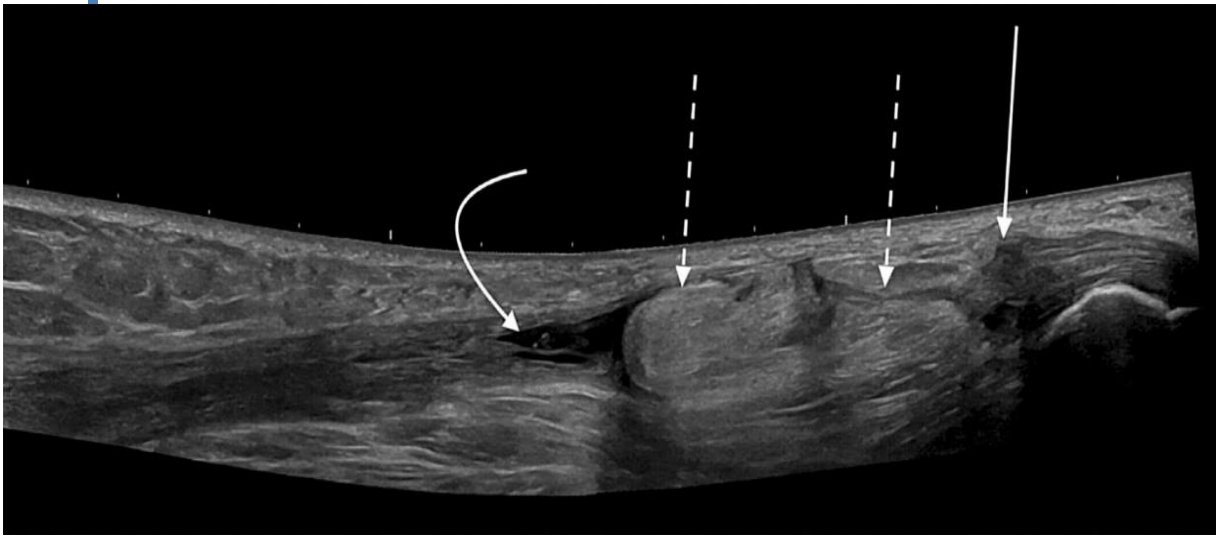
Longitudinal ultrasound image shows chronic full-thickness Achilles tendon tear. Distal end of tendon (*straight solid arrow*) is in normal position. Proximal end (*curved arrow*) is retracted with adjacent fluid. Fat from Kager fat pad (*dashed arrows*) is interposed in gap ⁽⁵⁾.
